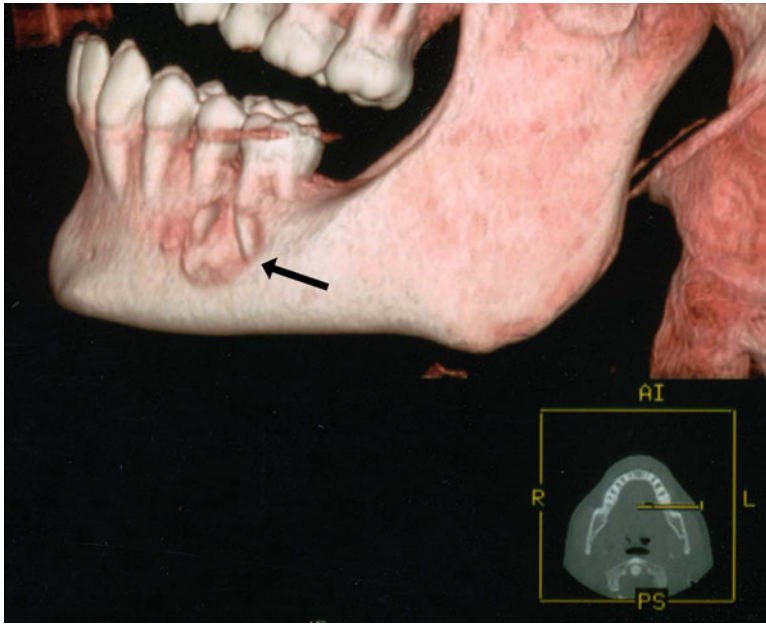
CT scan (reconstruction): ossifying fibroma of the left ramus of the mandible (*arrow*) in a young patient with hyperparathyroidism-jaw tumor syndrome
